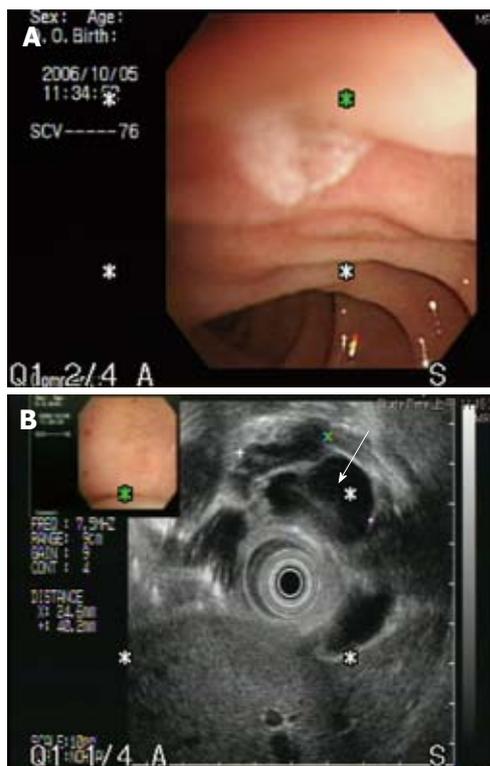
The endoscopic ultrasonography showed that the papilla of Vater was grossly normal without mucin discharge. However, a cystic tumor (arrow) measuring 4.0 cm x 4.2 cm in size was seen over the pancreatic head. The lining of cysts showed no definite projectile mass and the pancreatic duct was dilated about 0.6 cm in the head and 0.4 cm in the body and tail area.
